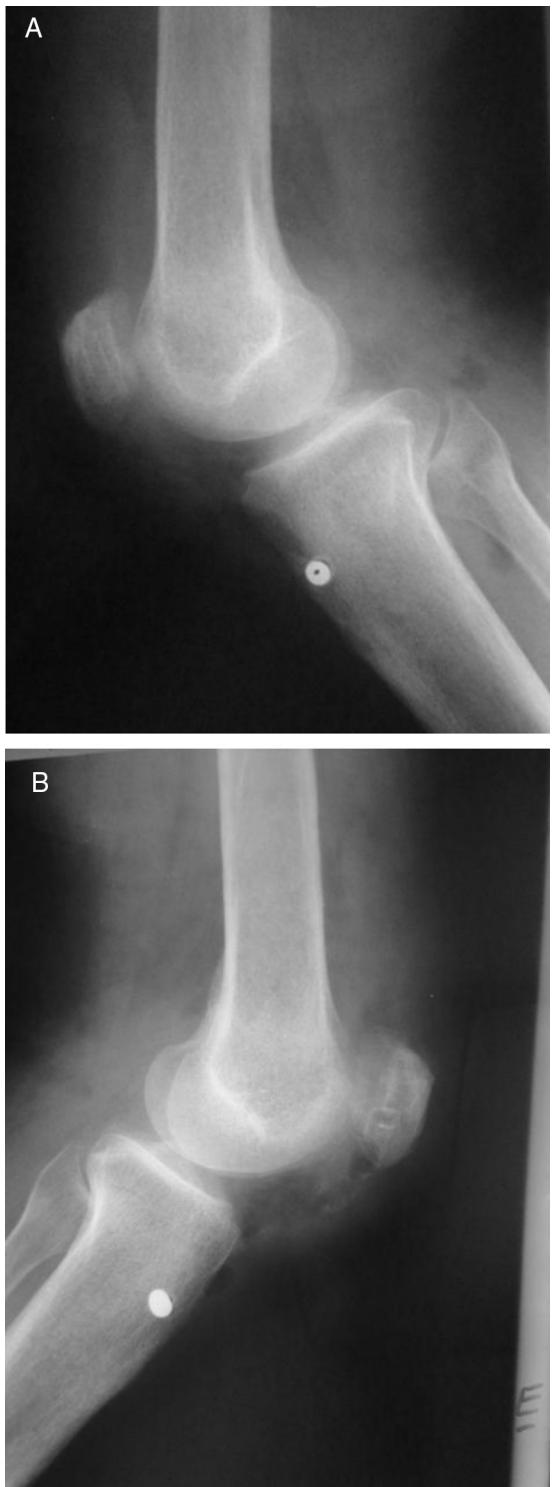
Transoperative radiographs showing good patellar positioning. (A) Left knee. (B) Right knee.
